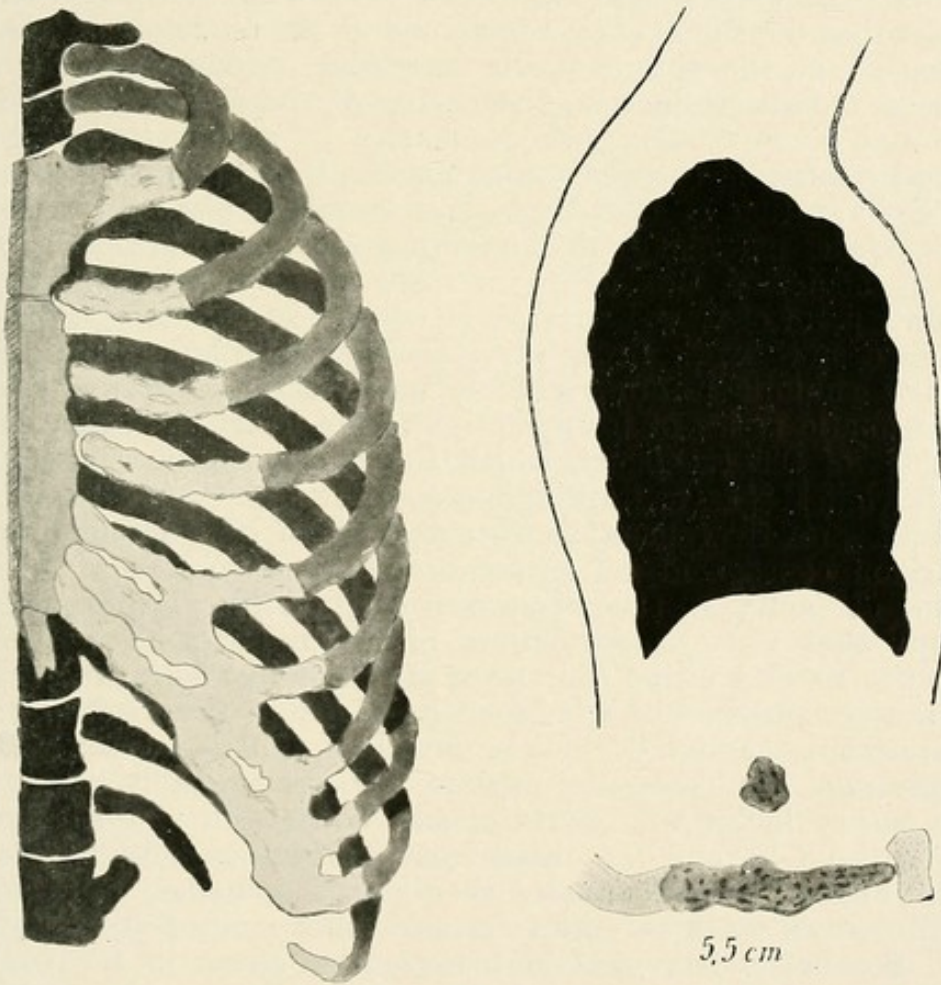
Rigidly dilated thorax. Parasternal longitudinal section with flattening of the diaphragm. Transverse and longitudinal section of a yellow fibrous cartilage, with irregular distension and perichondritic deposits (average length 5.5 cm.). (According to W. A. FREUND.)
